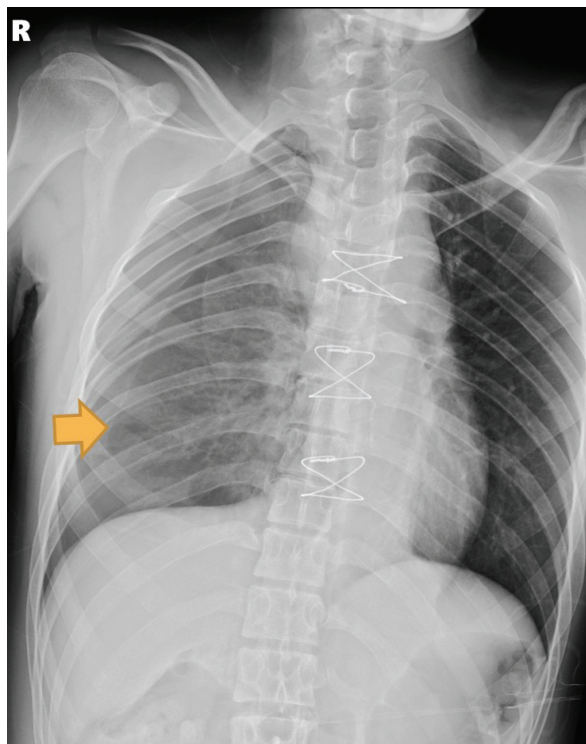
Hydropneumothorax can be seen in the chest x-ray.
